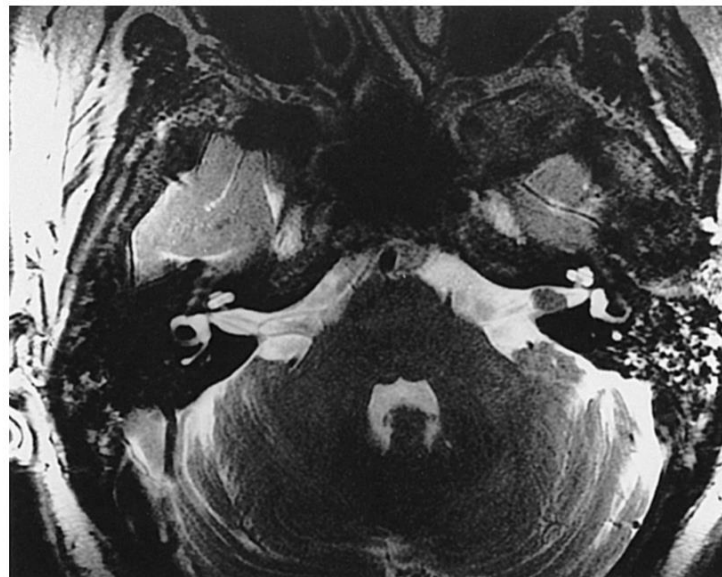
On T2-weighted fast spin echo magnetic resonance imaging, this axial reconstruction shows a 5-mm intracanalicular tumor (at left).
